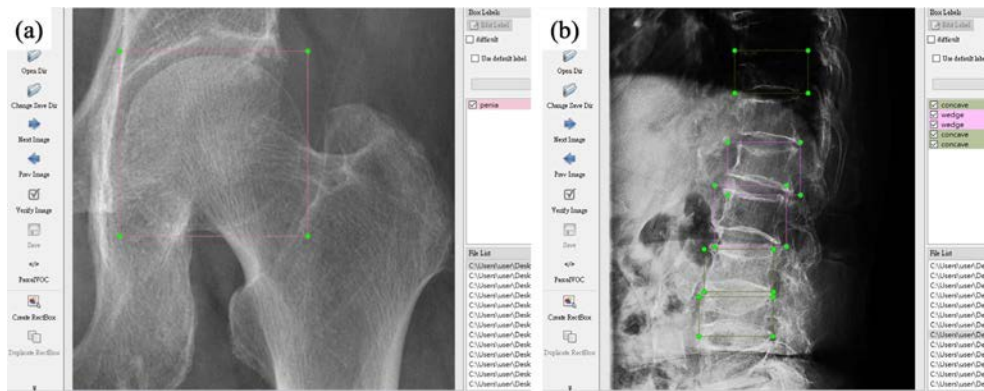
The labeled X-ray image of (a) osteoporosis using labelImage software and (b) compression fractures in the same way.
